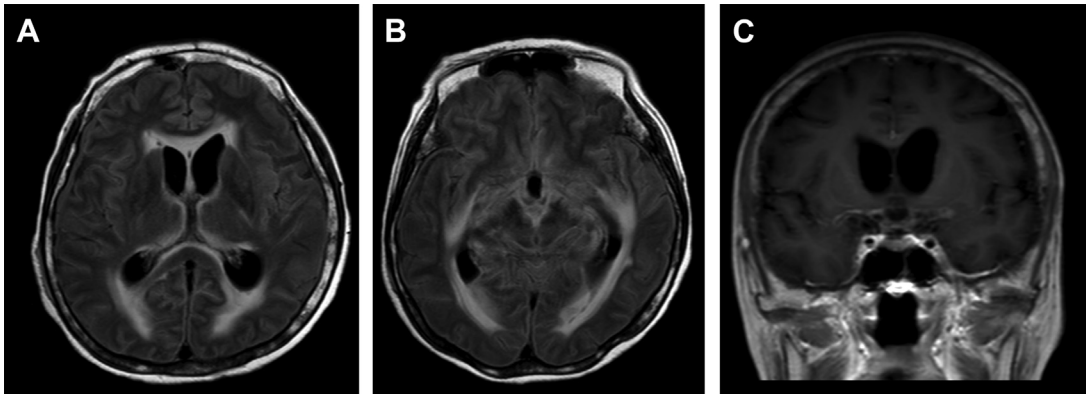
Tuberculous meningitis with secondary hydrocephalus. An axial FLAIR image shows the diffuse dilation of the bilateral lateral ventricle with periventricular hyperintensity from transependymal edema (A, B). Axial T1-weighted postcontrast MR imaging shows basal cisternal enhancement (C).
